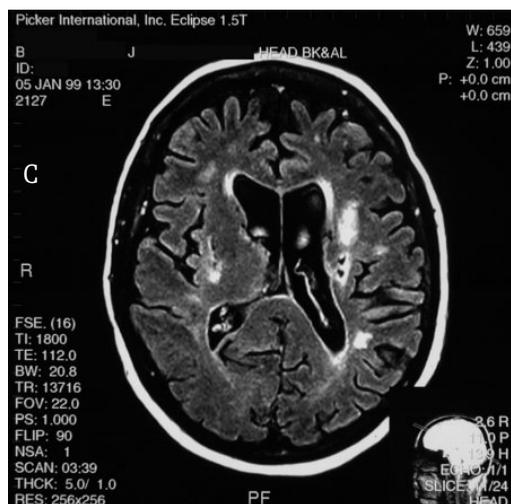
a, b, c. 58 year old man with 23 year history of SSc, complaining on memory loss and concentration deficits with deterioration of daily functions from 3 years; periodical severe headache and vertigo; episode of right sided haemiparesis 4 years ago: MRI, FSE, T2-weighted and FLAIR images: multiple, partially confluent focal lesions localized in periventricular and subcortical white matter as well as in deep structures of both haemispheres; moderate atrophy predominantly in frontal and frontotemporal regions.
